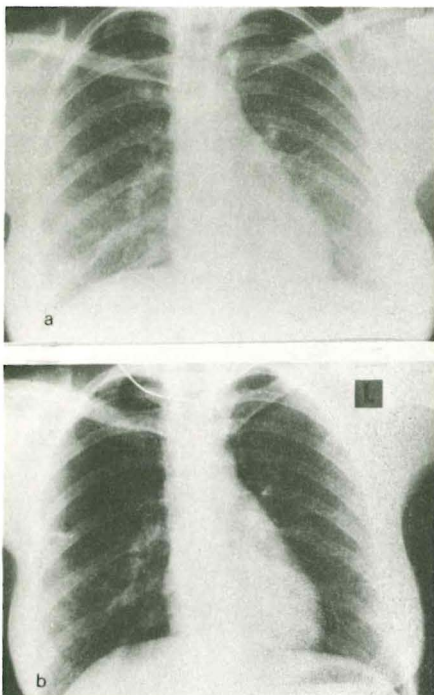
Chest X-ray films of Patient 1: (a) at the time of presentation (above); and (b) five weeks later (below) when symptoms had resolved. There has been complete resolution of the bilateral infiltrates.
